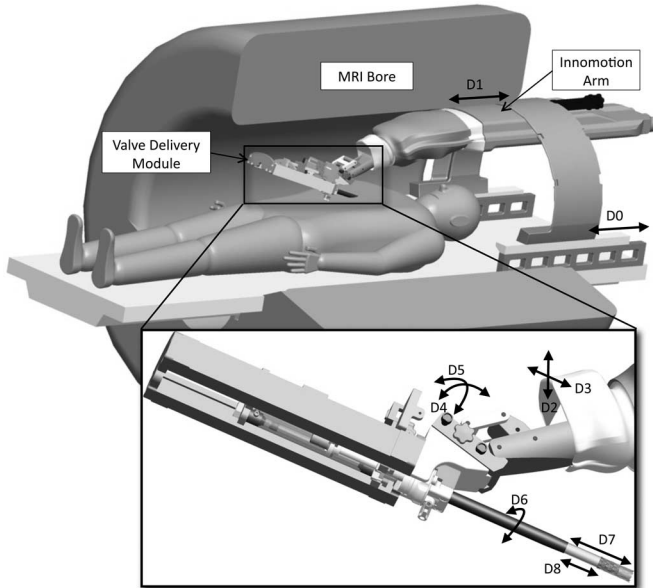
CAD sketch of the robotic system with patient inside an MRI bore.
